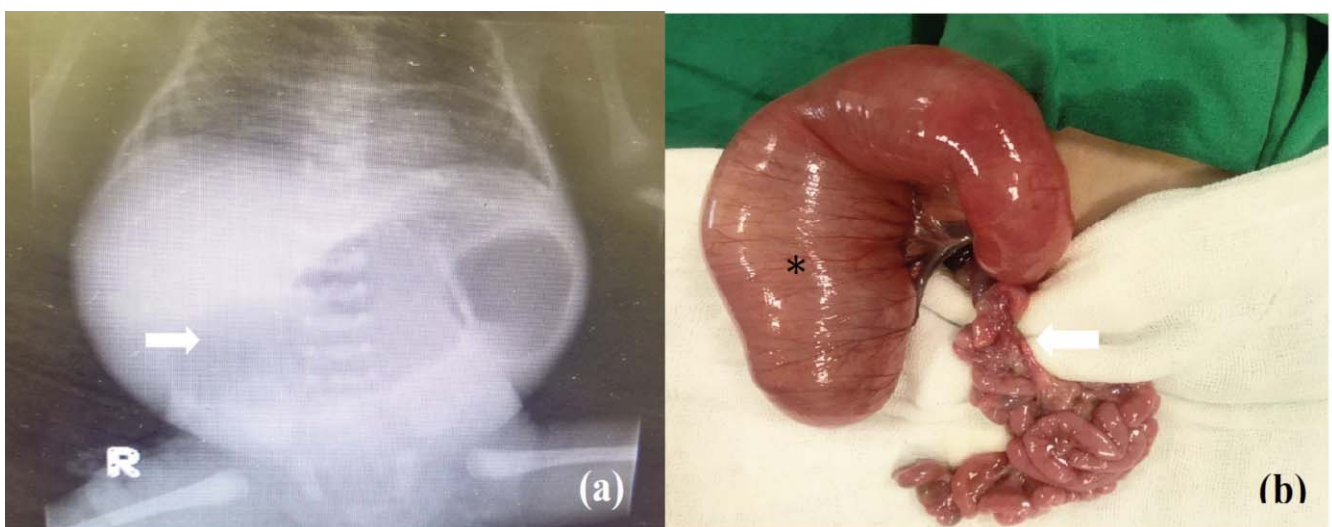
(a) Plain X-ray of the abdomen showing triple bubble sign (arrow), (b) Dilated duodenum and proximal jejuna loop (asterisk) with apple core type 3b jejunal Atresia (arrow)
